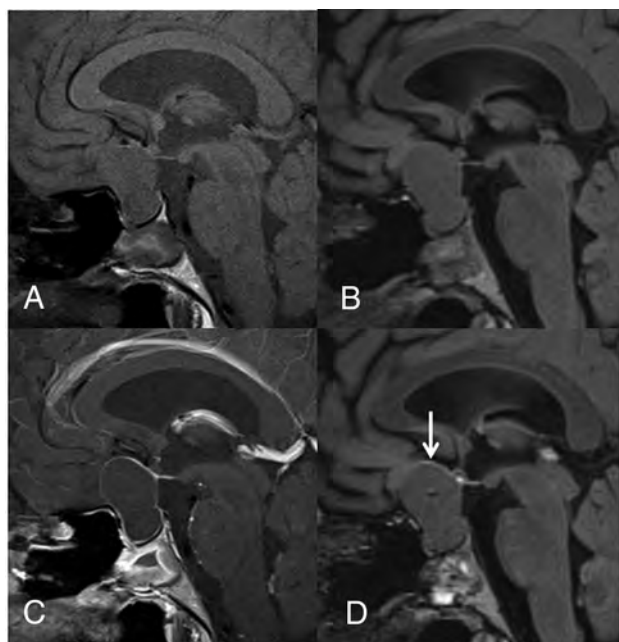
A 23-year-old woman with RCC. Compared with the precontrast T1WI (A), the postcontrast T1WI (C) demonstrates enhancement in most of the cyst wall (grade 2). Compared with the precontrast 3D T2-FLAIR image (B), the postcontrast 3D T2-FLAIR image (D) shows grade 1 enhancement of some of the cyst wall (arrow). In the blinded reading study, the confidence scale of this lesion was probably an RCC (scale 2) at both the first and second interpretation sessions.
